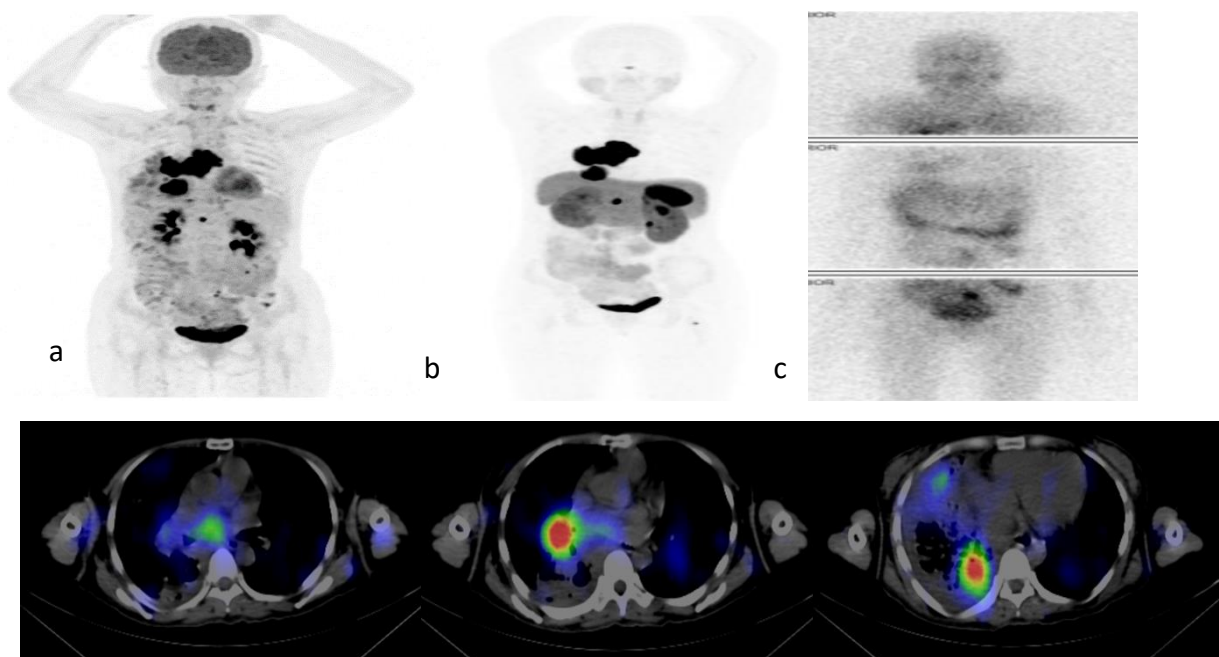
FDG, Ga68 DOTATATE, and I-131 MIBG scintigraphy of a 34-year-old lady with metastatic paraganglioma. a, b, c The number of lesions demonstrated MIP Ga68 DOTATATE images outnumber MIP FDG images and planar I-131 MIBG images, Ga68 DOTATATE showed uptake in the left femur but FDG PET/CT and I-131 MIBG planar images showed no tracer uptake. d I-131 MIBG SPECT/CT images show MIBG-avid disease at the subcarinal, right hilar, and right lower lobe.
